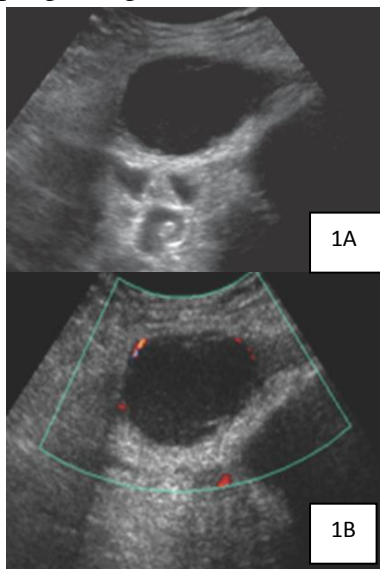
[A] Transabdominal pelvic USG image shows a hypoechoic mass with internal echoes in the left pelvic wall. [B] Color Doppler US image shows peripheral flow within the mass.
